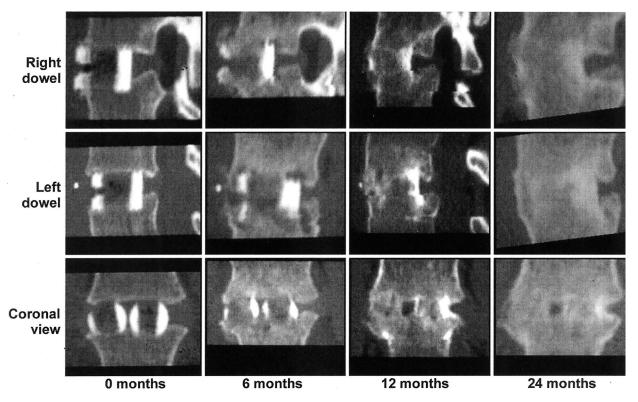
Serial thin-cut CT scans after an L5-S1 fusion using InFUSE™ Bone Graft. Sagittal and frontal CT reconstructions through both the right and left dowels show the progression of the interbody fusion. The immediate postoperative reconstructions show that the dowels have not been incorporated into the vertebral end plates, and there is no bone formation in the central portion of the dowels. At six months, the dowels are incorporated into the vertebral end plates, and there is new bone formation within the dowels. At 12 months, there is new bone formation connecting the adjacent vertebral bodies both inside and outside of the dowels. At 24 months, the dowels have almost been completely reabsorbed and replaced with new trabecular bone formation.
